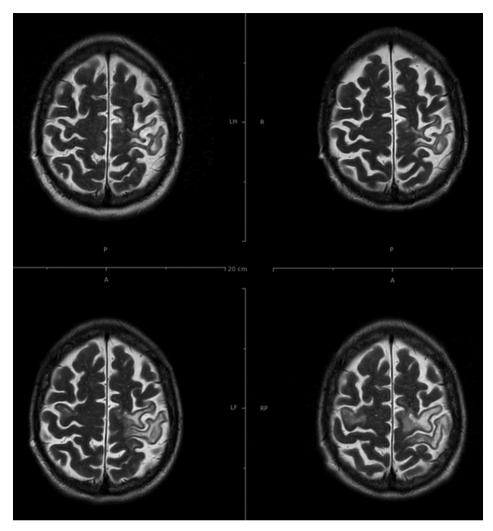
In the magnetic resonance imaging (MRI) scan, typical progressive multifocal leukoencephalopathy-associated lesions are seen in the precentral gyrus (right and left hemisphere) and in the postcentral gyrus (left hemisphere).
